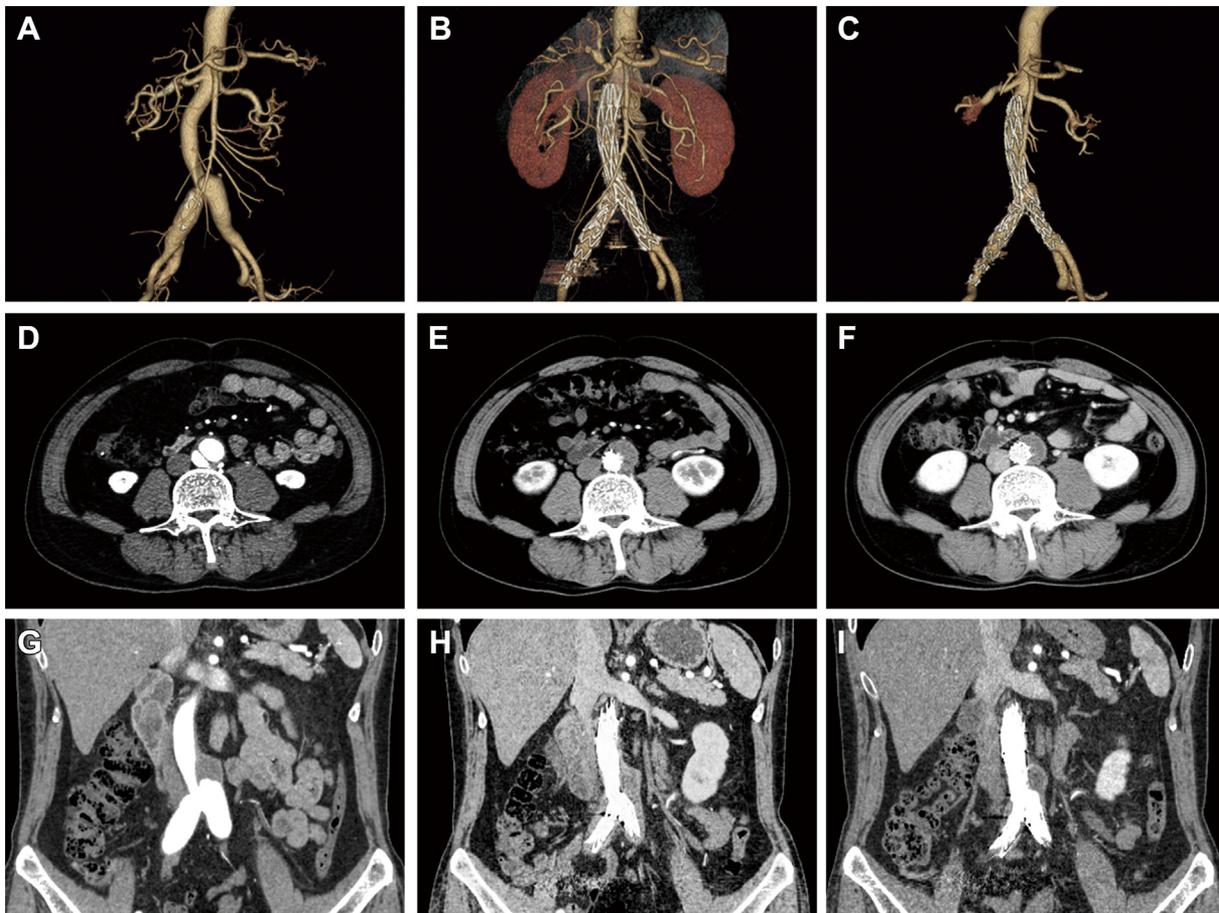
Representative computed tomography scans of the enrolled patients in this study. (A, D, and G) Before EVAR; (B, E, and H) at 3-month follow-up; and (C, F, and I), at 1 year follow-up.
